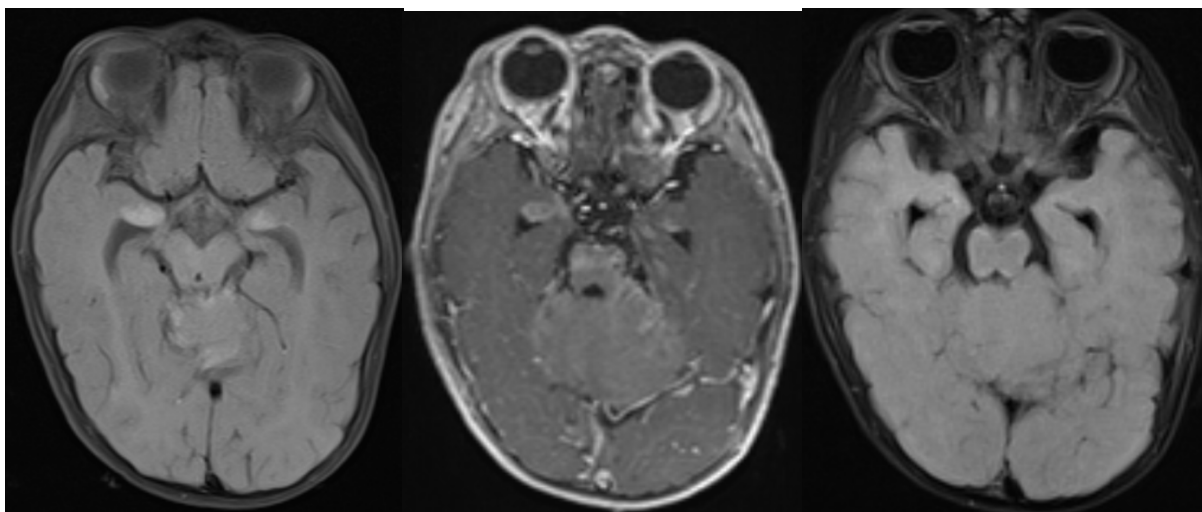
T1 weighted axial, T1 post contrast images, T2 FLAIR images showing melanin deposition in bilateral amygdalae, ventral pons and cerebellum.
